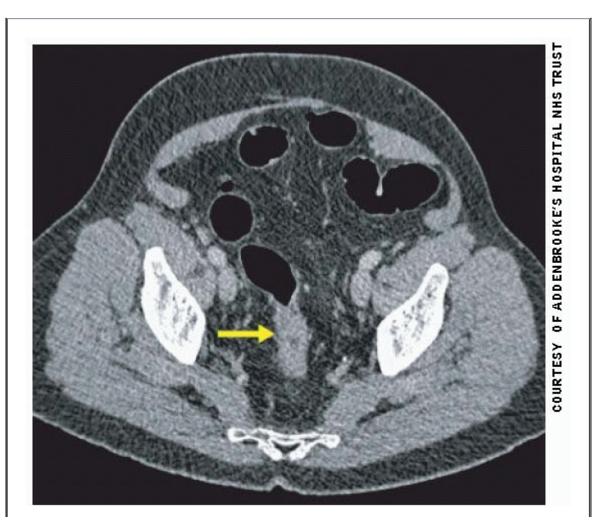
Axial CT colonogram: rectal thickening & stenosis (arrow) consistent with a rectal tumour.
